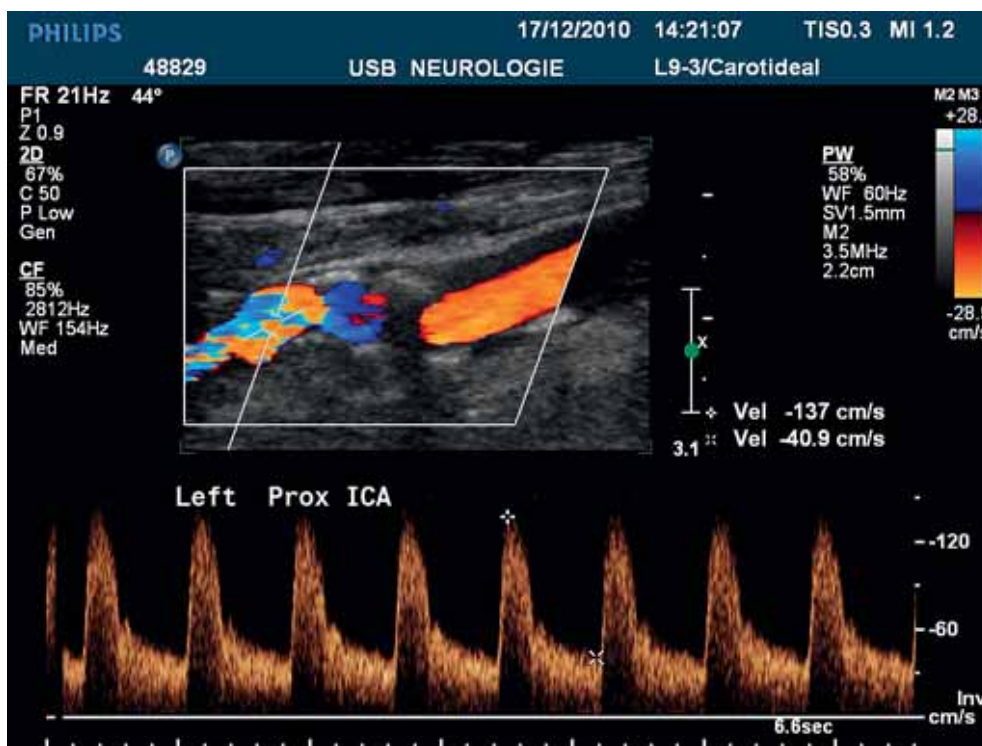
Sonographic image: left proximal internal carotid artery with low-grade stenosis due to mixed ecogenic plaques
